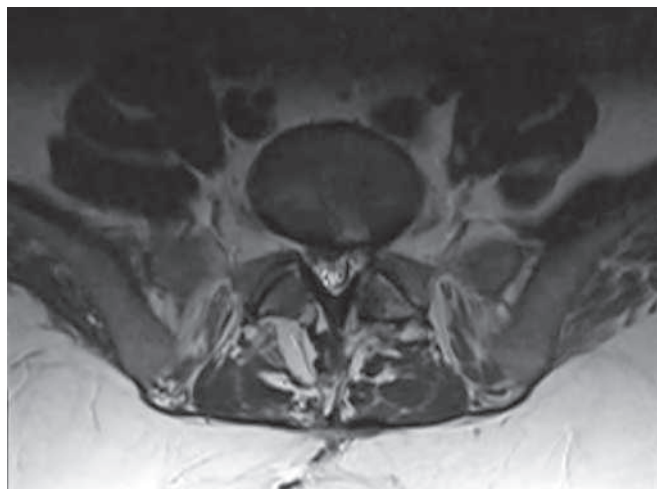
Axial T2 magnetic resonance imaging shows bulging degenerative disc with canal compromise.
